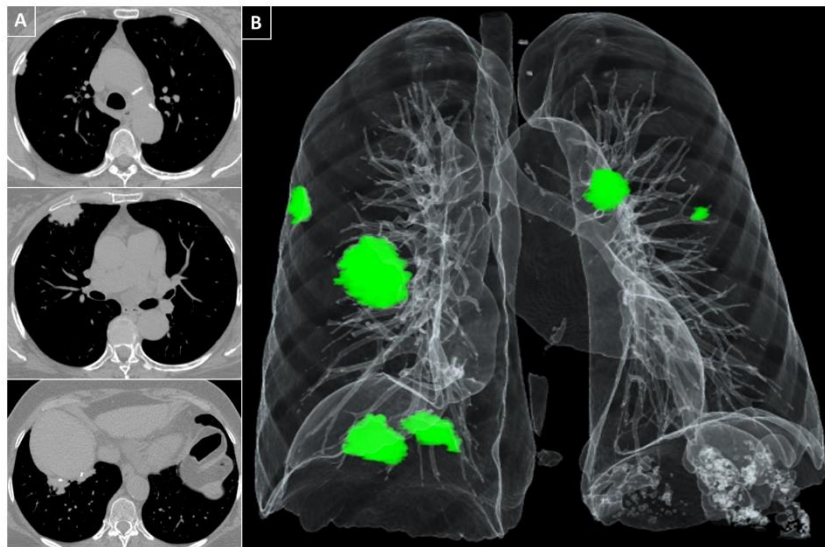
(A) Axial CT slices in a cranial-caudal sequence (from top to bottom) show bilateral pleural plaques. These protrude against the lungs, exhibiting lobulated margins and discrete calcifications. (B) A 3D volume rendering highlights the distribution of the plaques in both hemithoraces, depicted in green.
